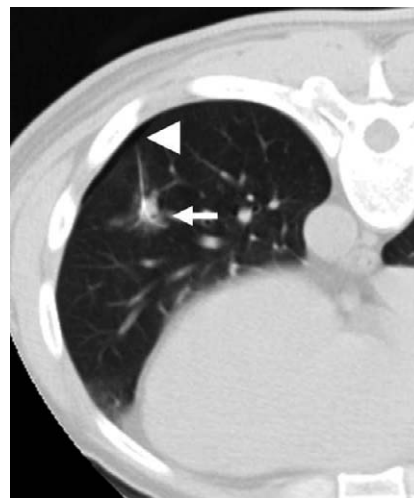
Prone computed tomography shows a left lower lobe, 17 mm deep subpleural lung nodule successfully localized by hook wire (white arrow). The arrowhead denotes minimal pneumothorax. The lesion was proved to be metastatic adenocarcinoma (patient 43).
